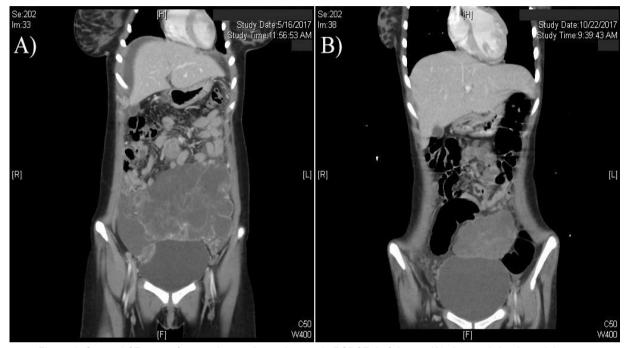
Coronal CT scan of pre and post chemotherapy in DSRCT. Left image (A) shows abdominopelvic mass 10.5 x 9 x 15 cm with peritoneal deposits and probably ovarian in origin. After eight cycles of chemotherapy, the mass was reduced in size significantly in the right image (B). That mass was inseparable from bladder and rectum in addition to bilateral moderate hydronephrosis and left common iliac vein compression.
